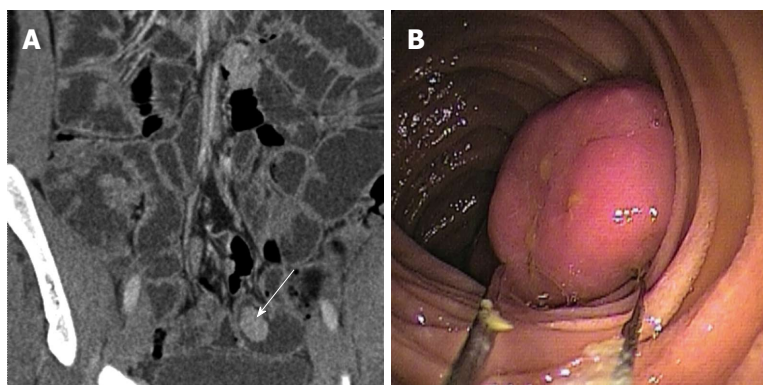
Polyp 4. A: Multidetector computed tomography (MDCT) coronal view reveals a regular small-bowel polyp with homogeneous enhancement (arrow); B: The double balloon endoscopy optimally depicts this large small bowel polyp.
